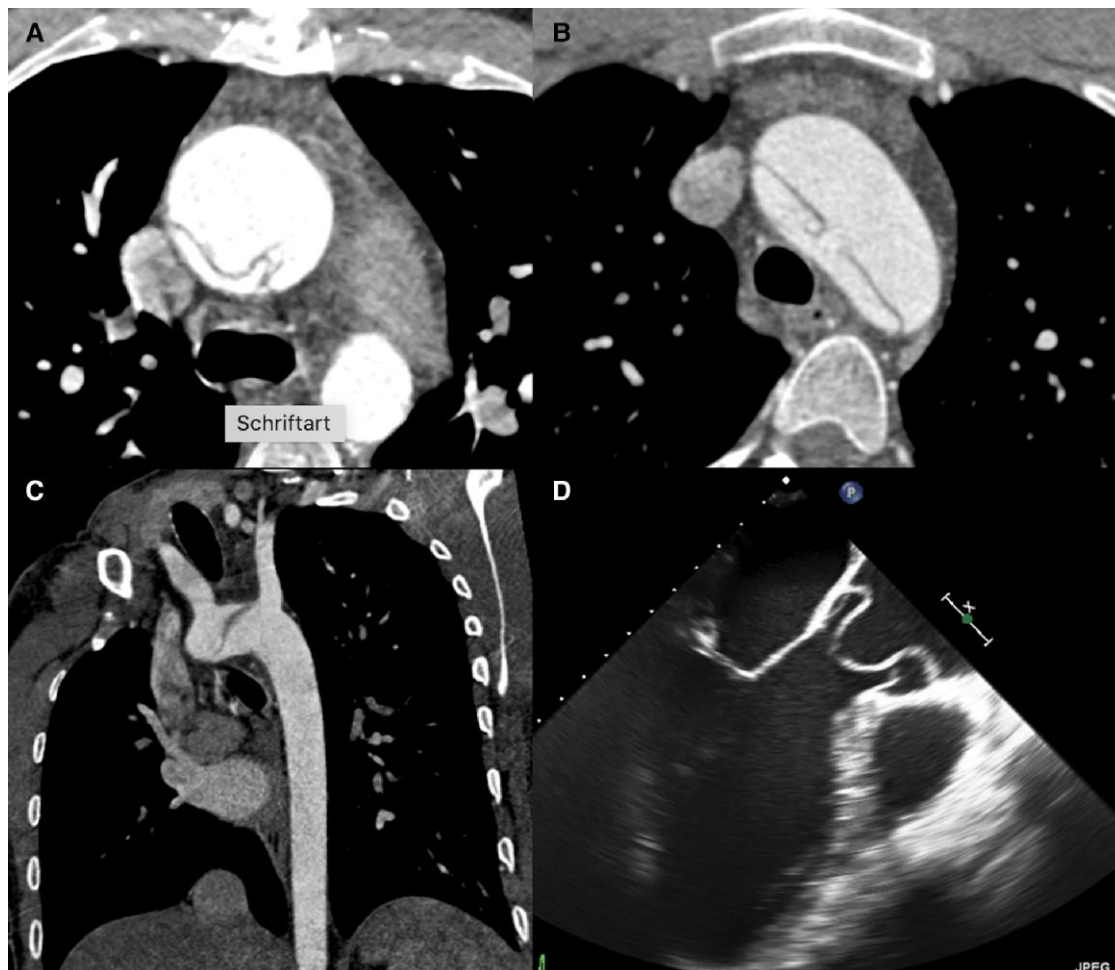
Type A aortic dissection in CTA (A–C) and TOE (D) (resolution: 300 dpi).
